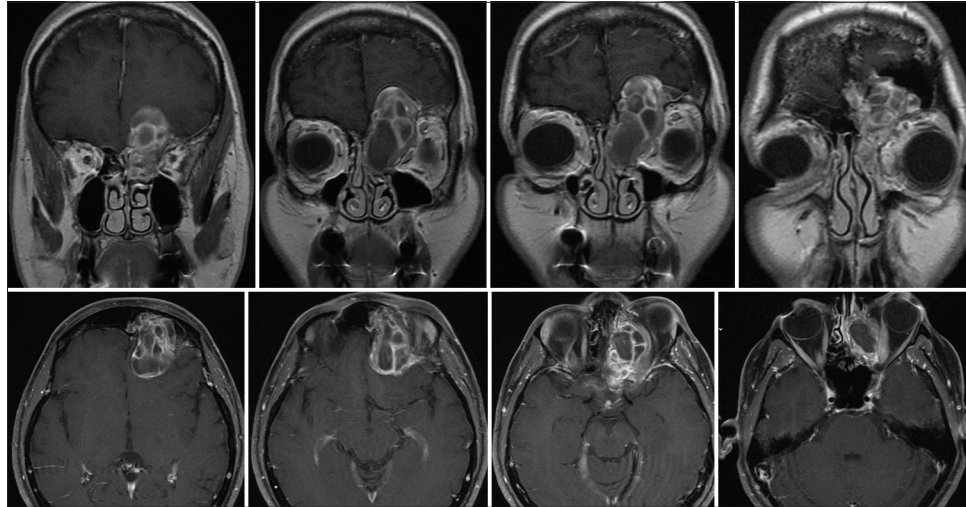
Preoperative coronal (up) and axial (down) brain T1-weighted Magnetic resonance imaging images after Gadolinium administration showing a left inhomogeneous multilobulated intradiploic fronto-orbito-ethmoidal lesion.
